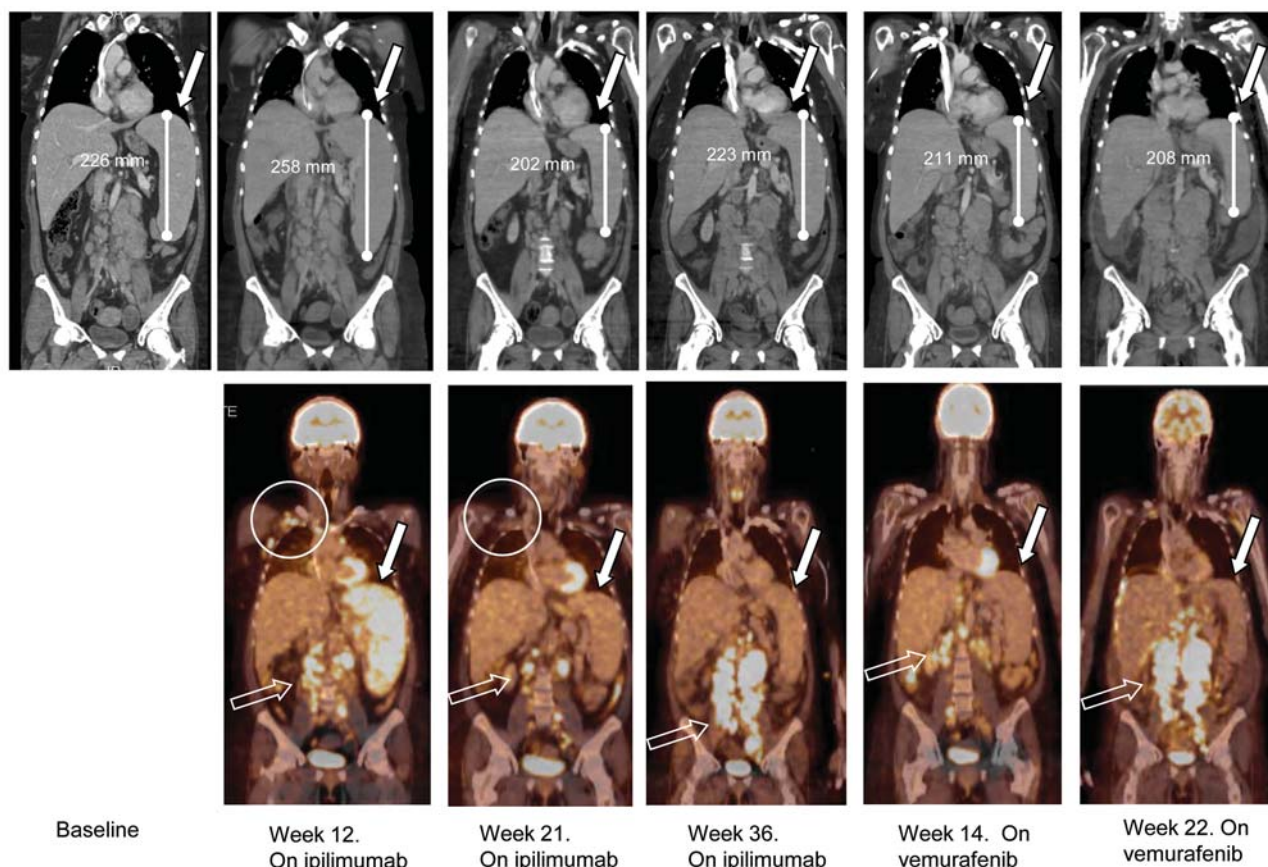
Coronal sections by computed tomography (CT) (upper panel), and ¹⁸Fluorodeoxy-D-glucose positron emission tomography/CT imaging (lower panel).
